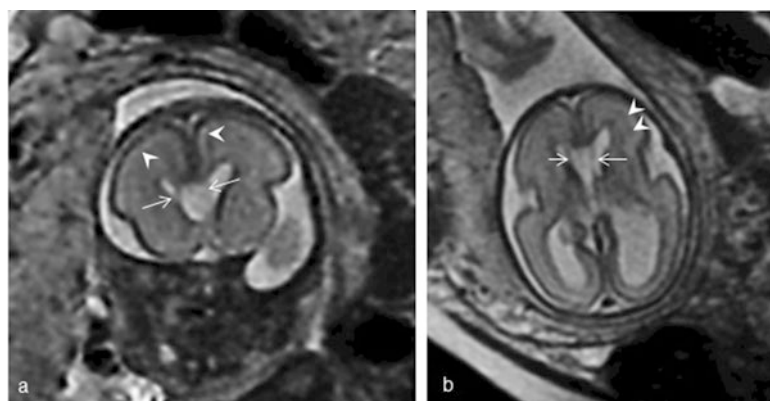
26 week GA fetus. (a) Coronal T2 weighted MRI. Arrow heads indicate the T2 bright subplate. (b) Axial T2 weighted MRI demonstrating a wide cavum septum pellucidum (arrows) with unilateral ventriculomegaly. Arrow heads indicate the T2 dark subventricular and intermediate zones
